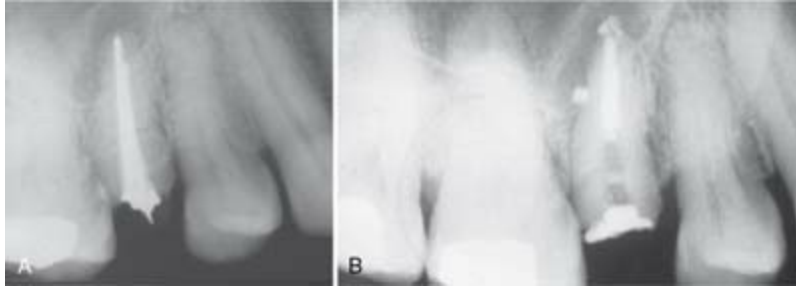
A, Preoperative view of a silver point case with persistent disease. Note that the periapical radiolucency extends coronally on the distal aspect of the root end indicating the presence of an unfilled lateral canal. B, Postobturation radiograph showing the cleaned and filled distal canal branch.
